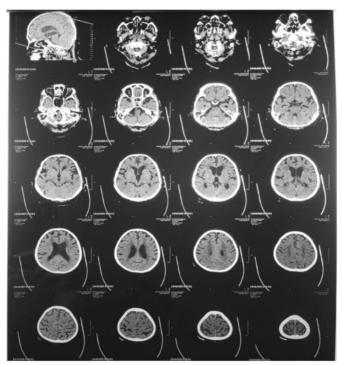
CT-scan result show a cerebrovascular accident (CVA) infarction
